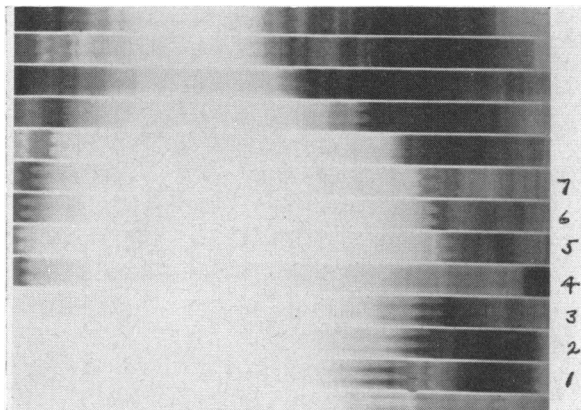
P.A. kymogram of male, age 54. Note the absence of normal waves in frame number 4 above the left hemidiaphragm ("silent" frame); and the reversed pattern in frames 5 to 7 ("paradoxical" motion). Roentgen diagnosis: myocardial damage, presumably infarction, involving the wall of the left ventricle. The patient was a physician with a clinical diagnosis of infarct. Autopsy verification 2½ weeks later.
